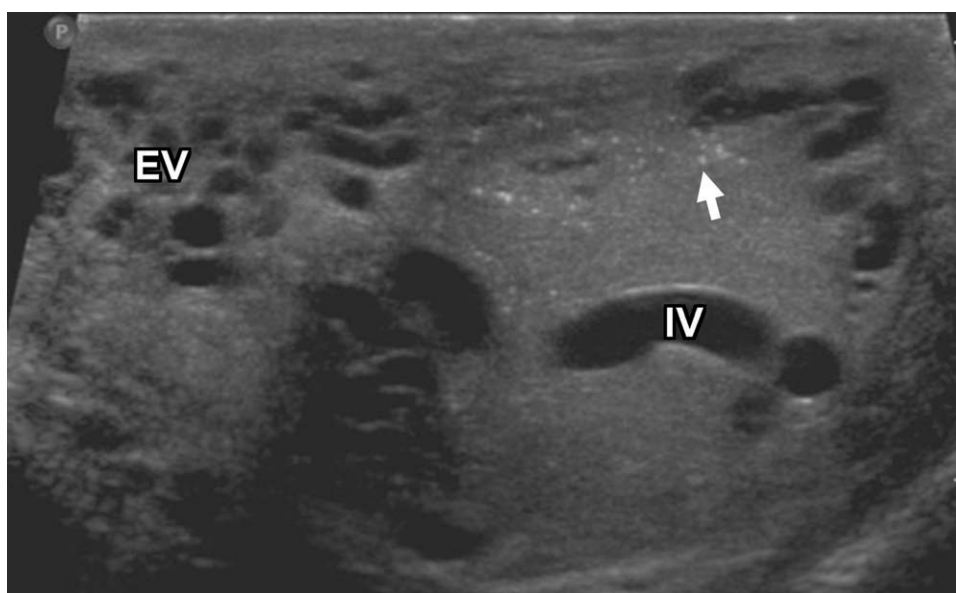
Transverse grayscale sonogram of the left testis shows microlithiasis (arrow). An extratesticular varicocele is present (EV), in addition to large anechoic structures within the testicular parenchyma representing an intratesticular varicocele (IV).
